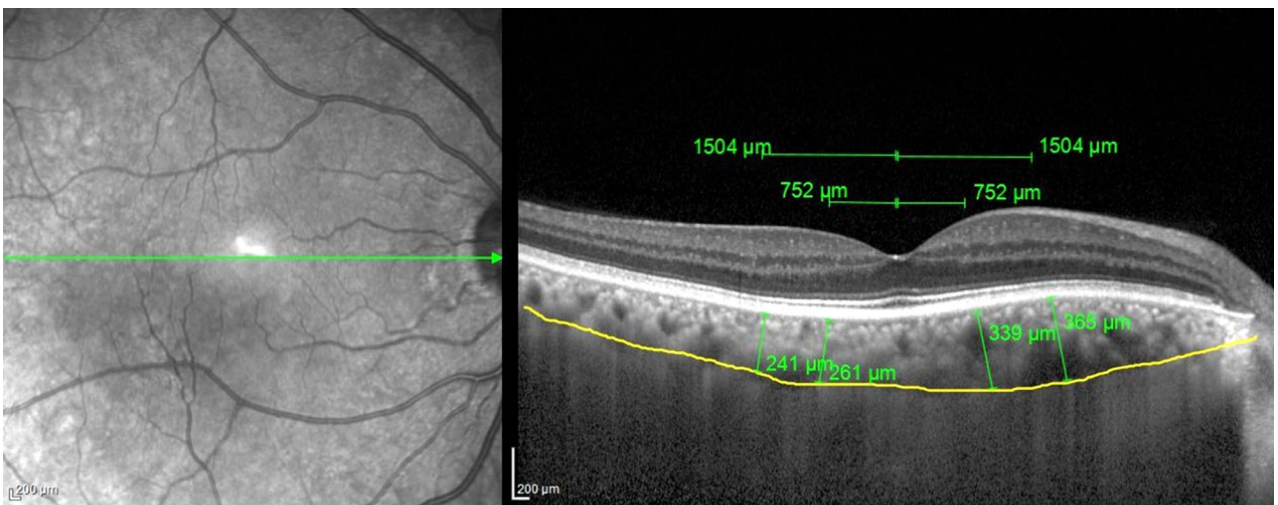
Enhanced-depth imaging optical coherence tomographic images of a healthy subject. Yellow lines show CT measurements taken perpendicularly from the outer edge of the hyperreflective retinal pigment epithelium. The CT was measured at four points: the 750 μm nasal and temporal to the fovea, 1500 μm nasal and temporal to the fovea. CT: Choroidal thickness.
